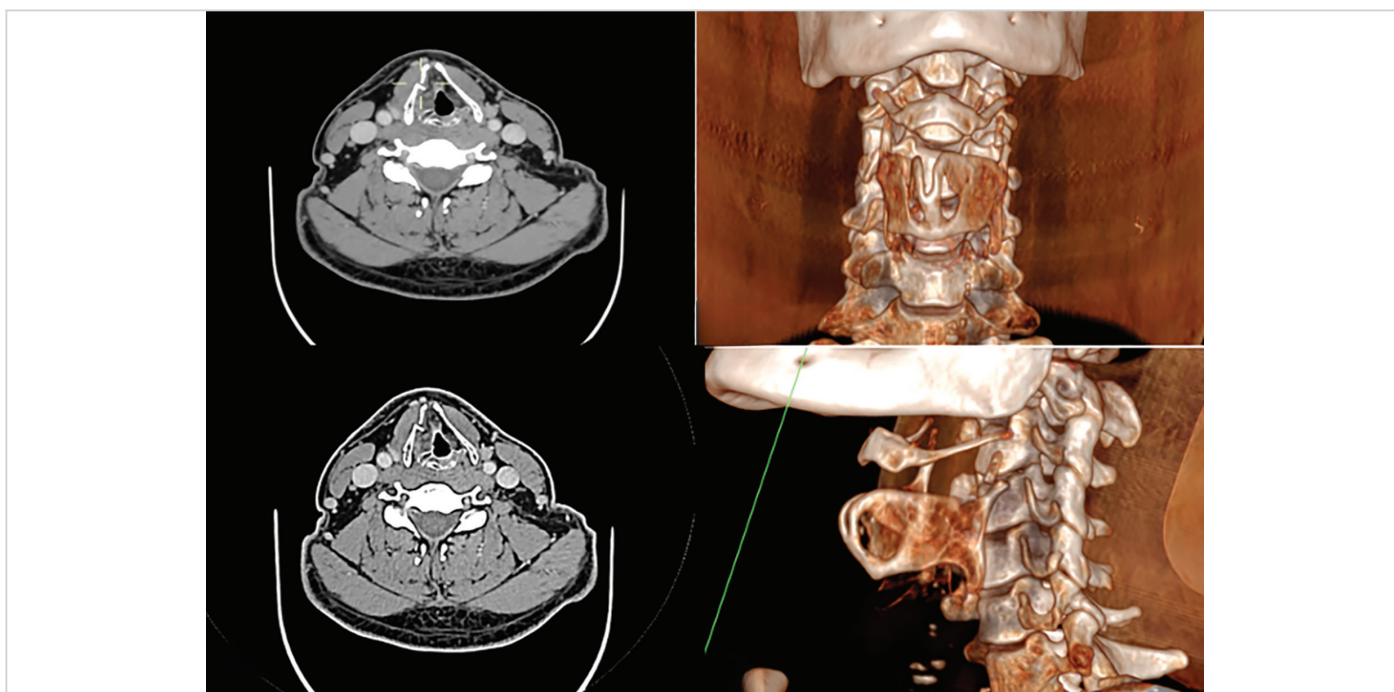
Computed tomography images of displaced comminuted fracture of the right thyroid cartilage with a fracture fragment displaced inwards
